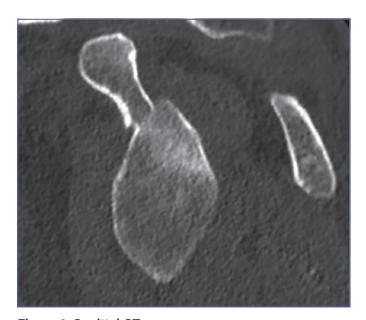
Sagittal CT scan.
